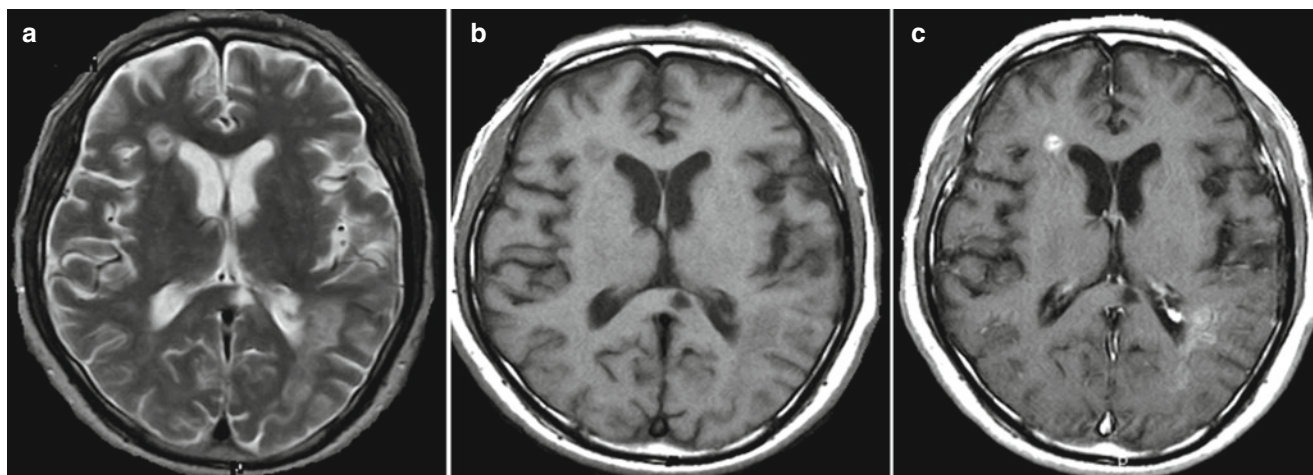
Multiple sclerosis in an active stage. Several small lesions located in the vicinity of the lateral ventricles present with low signal intensity on T2-weighted (a) and isointensity on T1-weighted (b) images, perifocal edema, and prominent contrast enhancement (c)
